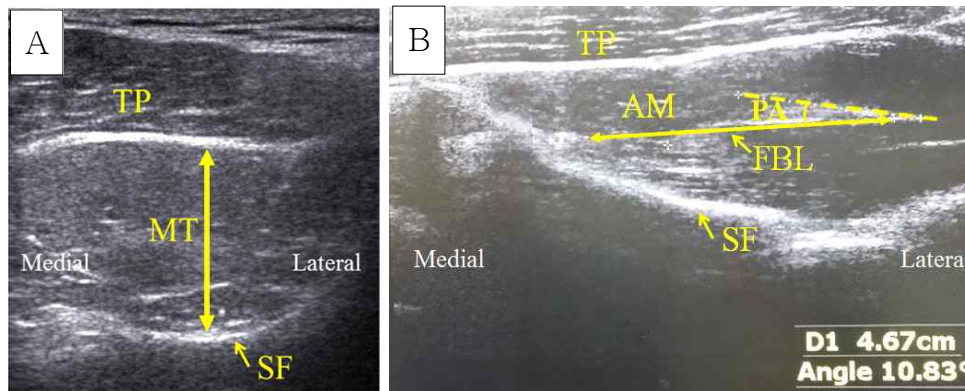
Ultrasound scans of the right supraspinatus in the resting position. (A) sagittal scan, (B) longitudinal scan (MT: muscle thickness, SF: supraspinous fossa, TP: trapezius, AM: middle region of anterior part, PA: pennation angle, FBL: fiber bundle length).
